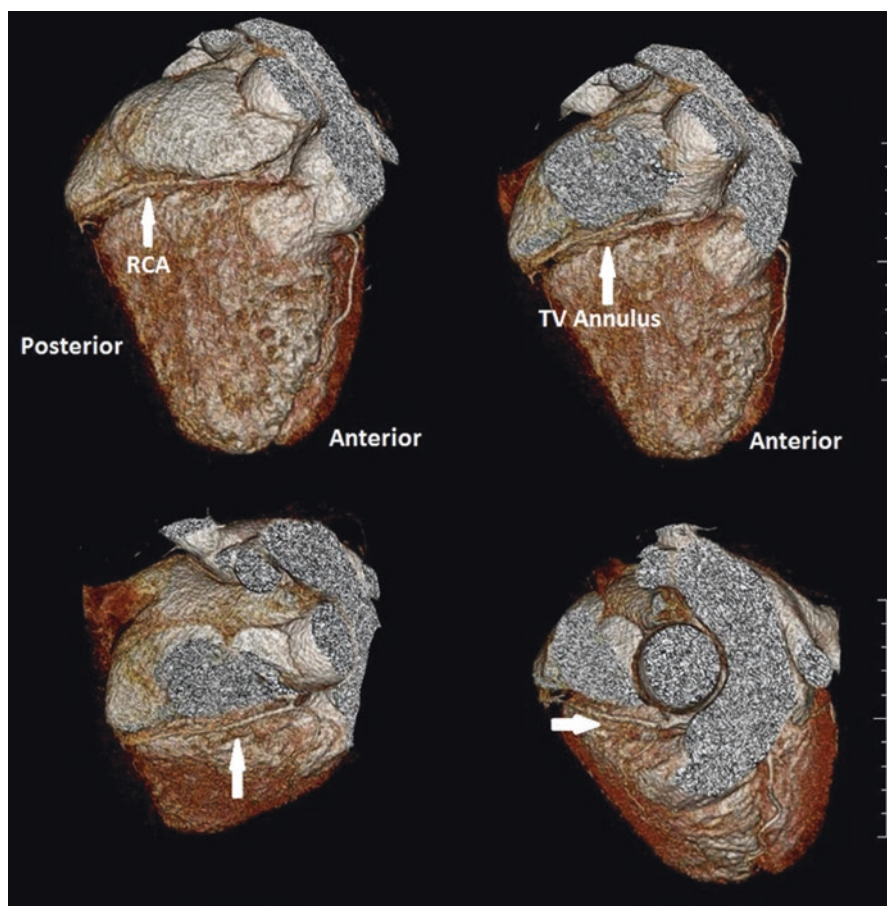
Computed Tomography analysis of the right coronary artery. 3D reconstructions with computed tomography showing the relationship between the right coronary artery and the tricuspid valve annulus
